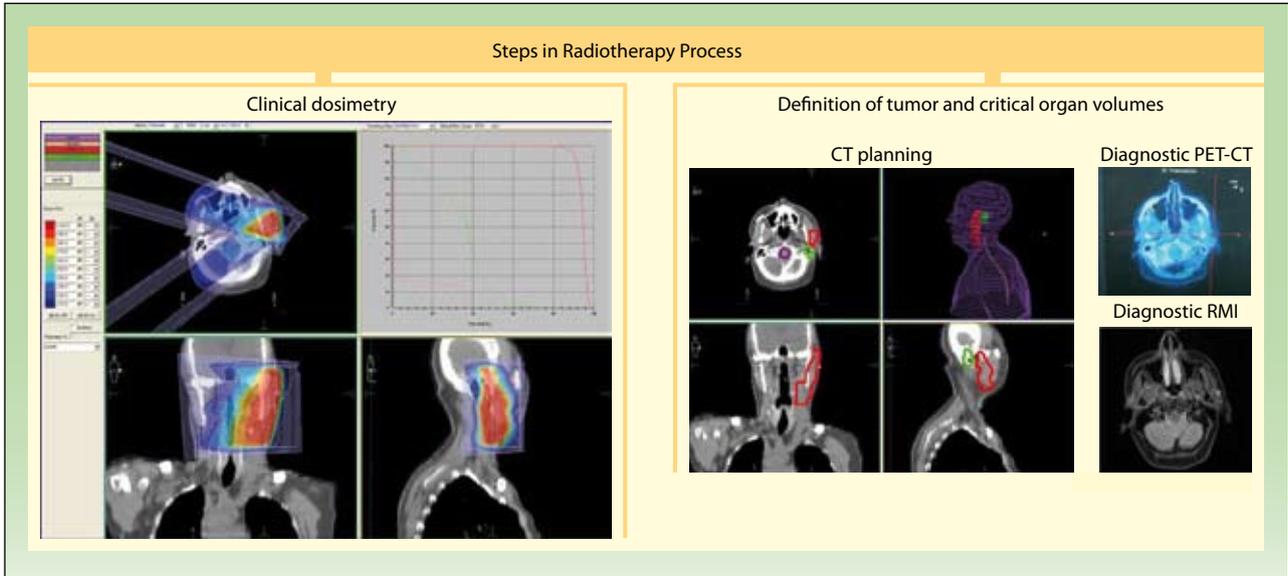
Steps in radiotherapy process. Irradiation of cervical-parotid lymph node metastasis from squamous cell carcinoma of the skin. Localization of tumor with the aid of positron emission tomography-computerized tomography (PET-CRT) and magnetic resonance imaging (MRI). Definition of target volumes and clinical dosimetry on CT planning scans.
